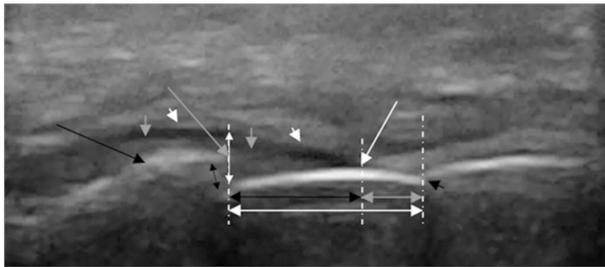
Ultrasound examination 40 MHz, longitudinal section, buccal surface, on tooth axis. Gingival epithelium (short white arrow), hypoechogenic connective tissue (short gray arrow), hyperechogenic cortical bone (long black arrow), cement–enamel junction (short black arrow), free gingival margin (long white arrow), alveolar crest (long gray arrow), gingival recession (UGR) distance between cement–enamel junction and gingival free margin (gray double arrow), UBJ distance between alveolar crest and cement–enamel junction (white long double arrow), UWPS periodontal space width (black short double arrow), UBG distance between alveolar crest and free gingival margin (long black double arrow), UGW attached gingiva width/thickness at the alveolar crest limit (white short double arrow).
